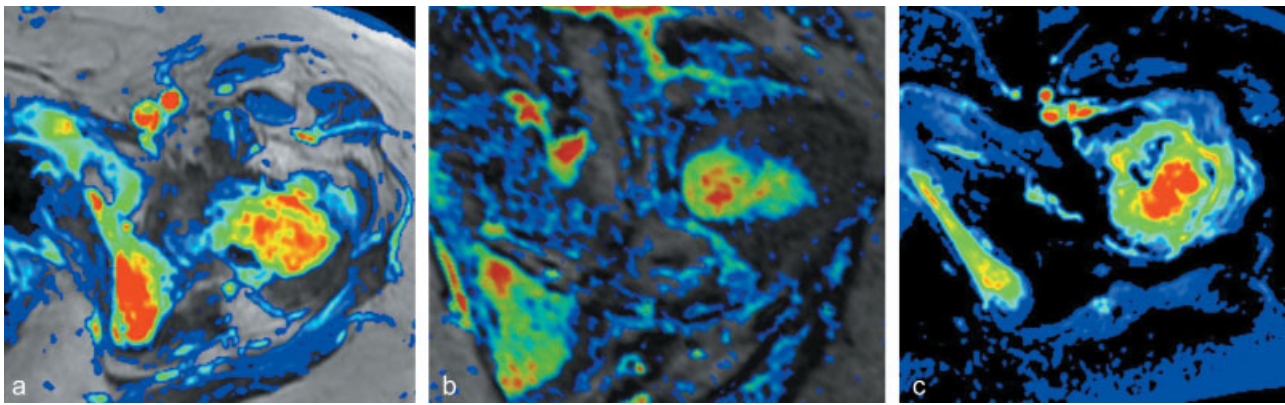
(a) Preprocedural dynamic contrast-enhanced MRI showing highly vascularized bone metastasis on left ischiopubic ramus and left femoral neck of a 57-year-old man with colon carcinoma; the colorimetric map obtained from perfusion sequences clearly shows the lesions in yellow and red. (b) Immediately after treatment, MRI control shows a significant reduction in lesion vascularity, demonstrating an effective local tumor control. This patient reported a significant reduction of symptoms as well (from a baseline VAS score of 8 to a postoperative value of 2, starting from the following day). (c) However, at 6 months, MRI follow-up shows an increase in vascularization intensity and extent (particularly on the femur), which indicates disease progression; despite this condition, this patient continued to benefit from pain relief (VAS score of 2).
